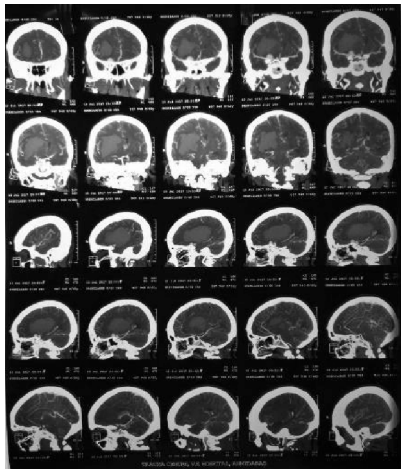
CT Angiography brain
